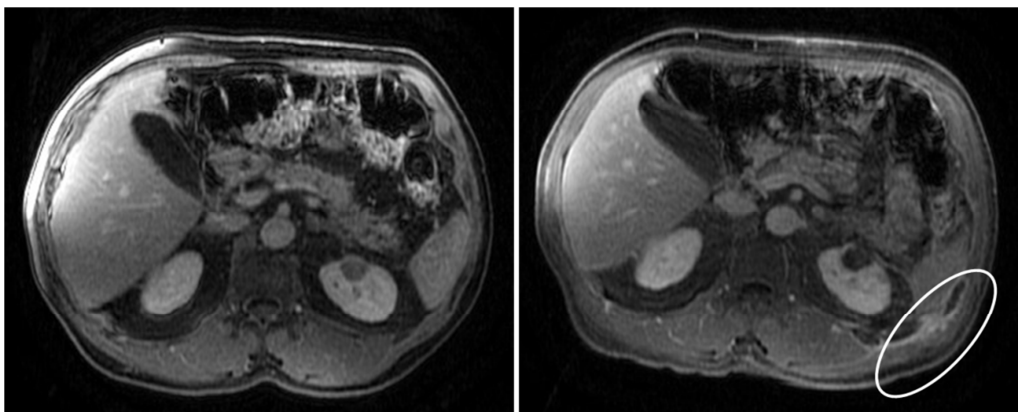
Pre-HIFU (left) and post-HIFU (right) MRI of Patient 5.01 demonstrating extensive abdominal wall swelling (circled) still present 12 days after treatment
